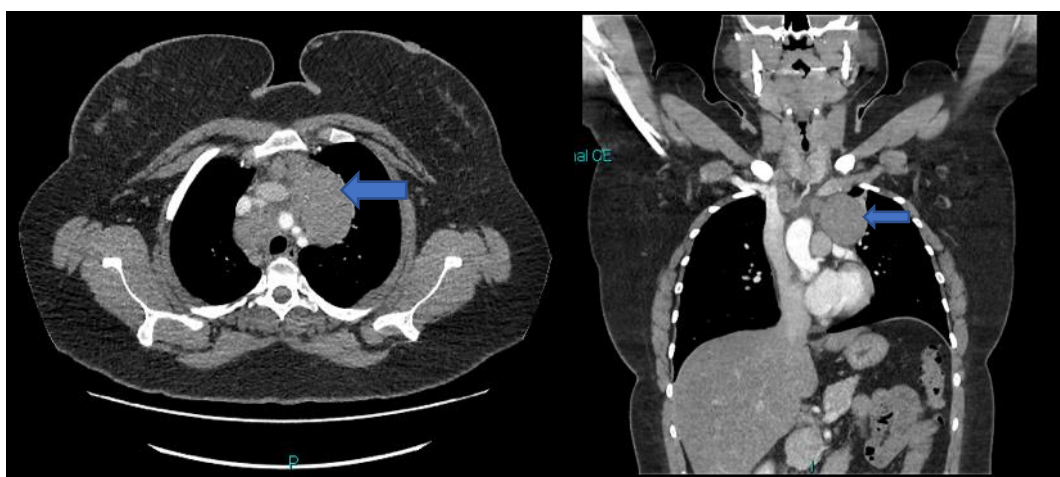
Axial and coronal CT scan showing a left anterior mediastinal mass (blue arrow) in 25 year old female.
